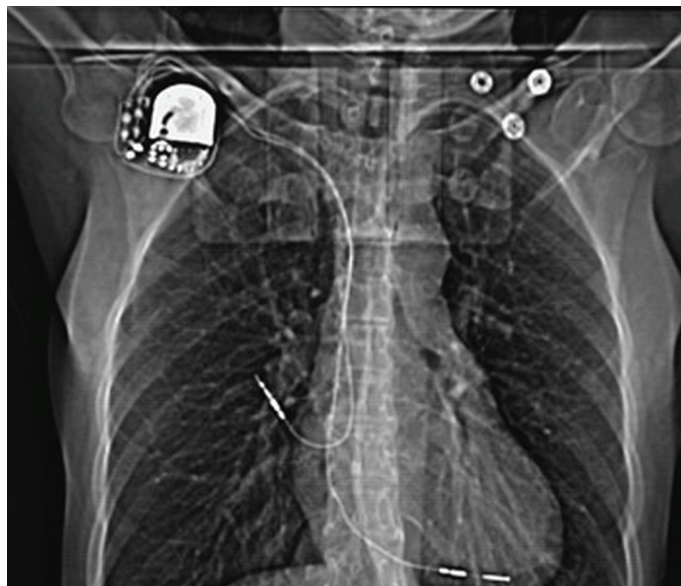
Chest X-ray demonstrating severe lead perforation due to implantable cardioverter-defibrillator implantation.
